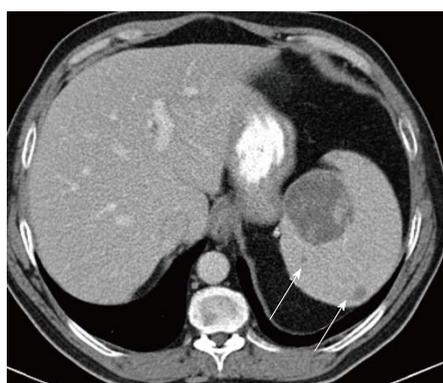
Splenic mass on computed tomography. Axial computed tomography image shows a large low density mass with patchy foci of soft tissue density within it in the medial aspect of the spleen. Additional smaller low density masses are present as well (arrows).
